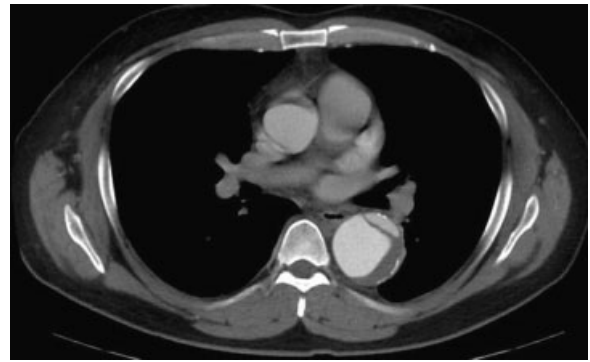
Contrast computed tomographic findings after the disaster.
